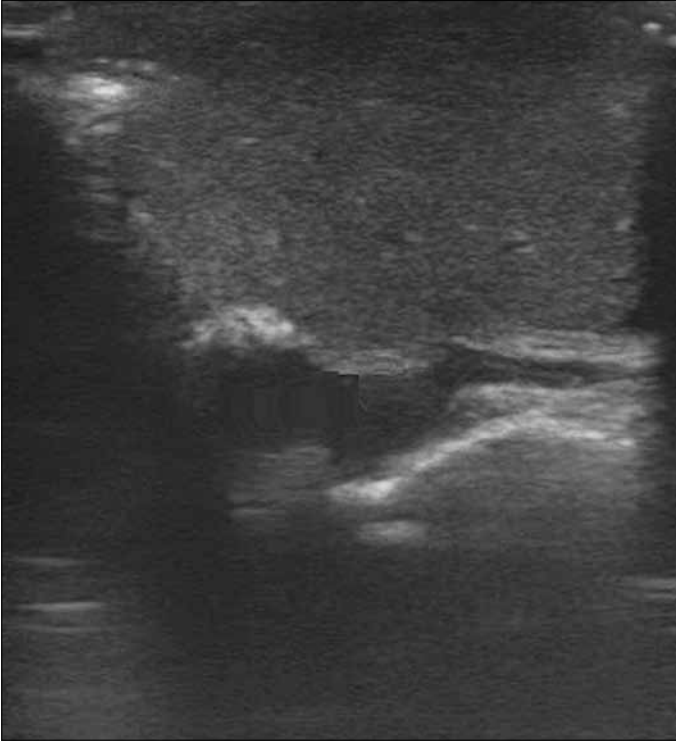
Intraoperative ultrasound imaging shows no visible residual tumor
